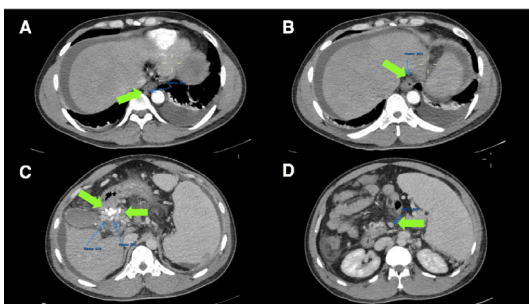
CT Angiogram. A&B: Persistent nodular enhancement along the lumen of the distal esophagus may be from esophageal variceal formation; C: Hyperdensities within the duodenum, region of the gallbladder, porta hepatis and right hepatic lobe parenchyma, which likely relates to post-surgical material; D: Persistent small filling defects at the region of the portal vein suggestive of thrombosis.
